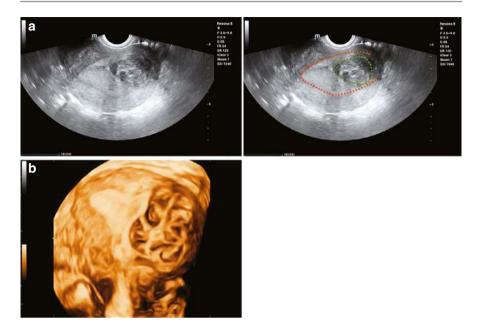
(a) Type 2 intramural fibroid protruding into the submucosa: 2D ultrasound shows a fibroid in the left wall of the uterus, most of which lies intramurally, with a localized protrusion into the mucosa. The orange dotted line marks the endometrium; the green circle marks the fibroid. (b) Type 2 fibroid: The coronal plane of the uterus on 3D ultrasound provides a stereoscopic visualization of the fibroid in relation to the endometrium and shows the protrusion of the fibroid into the lower segment of the uterine cavity
